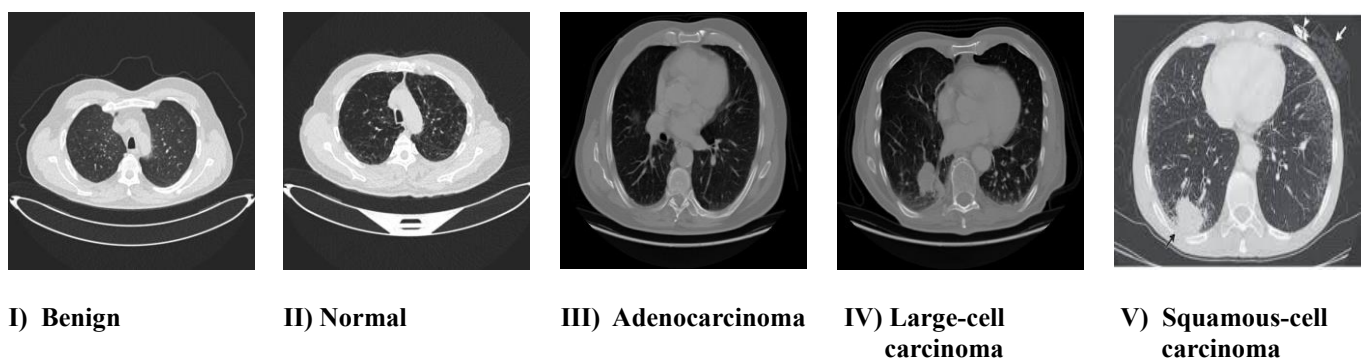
Representative CT images from the combined lung cancer dataset [19] [20]
